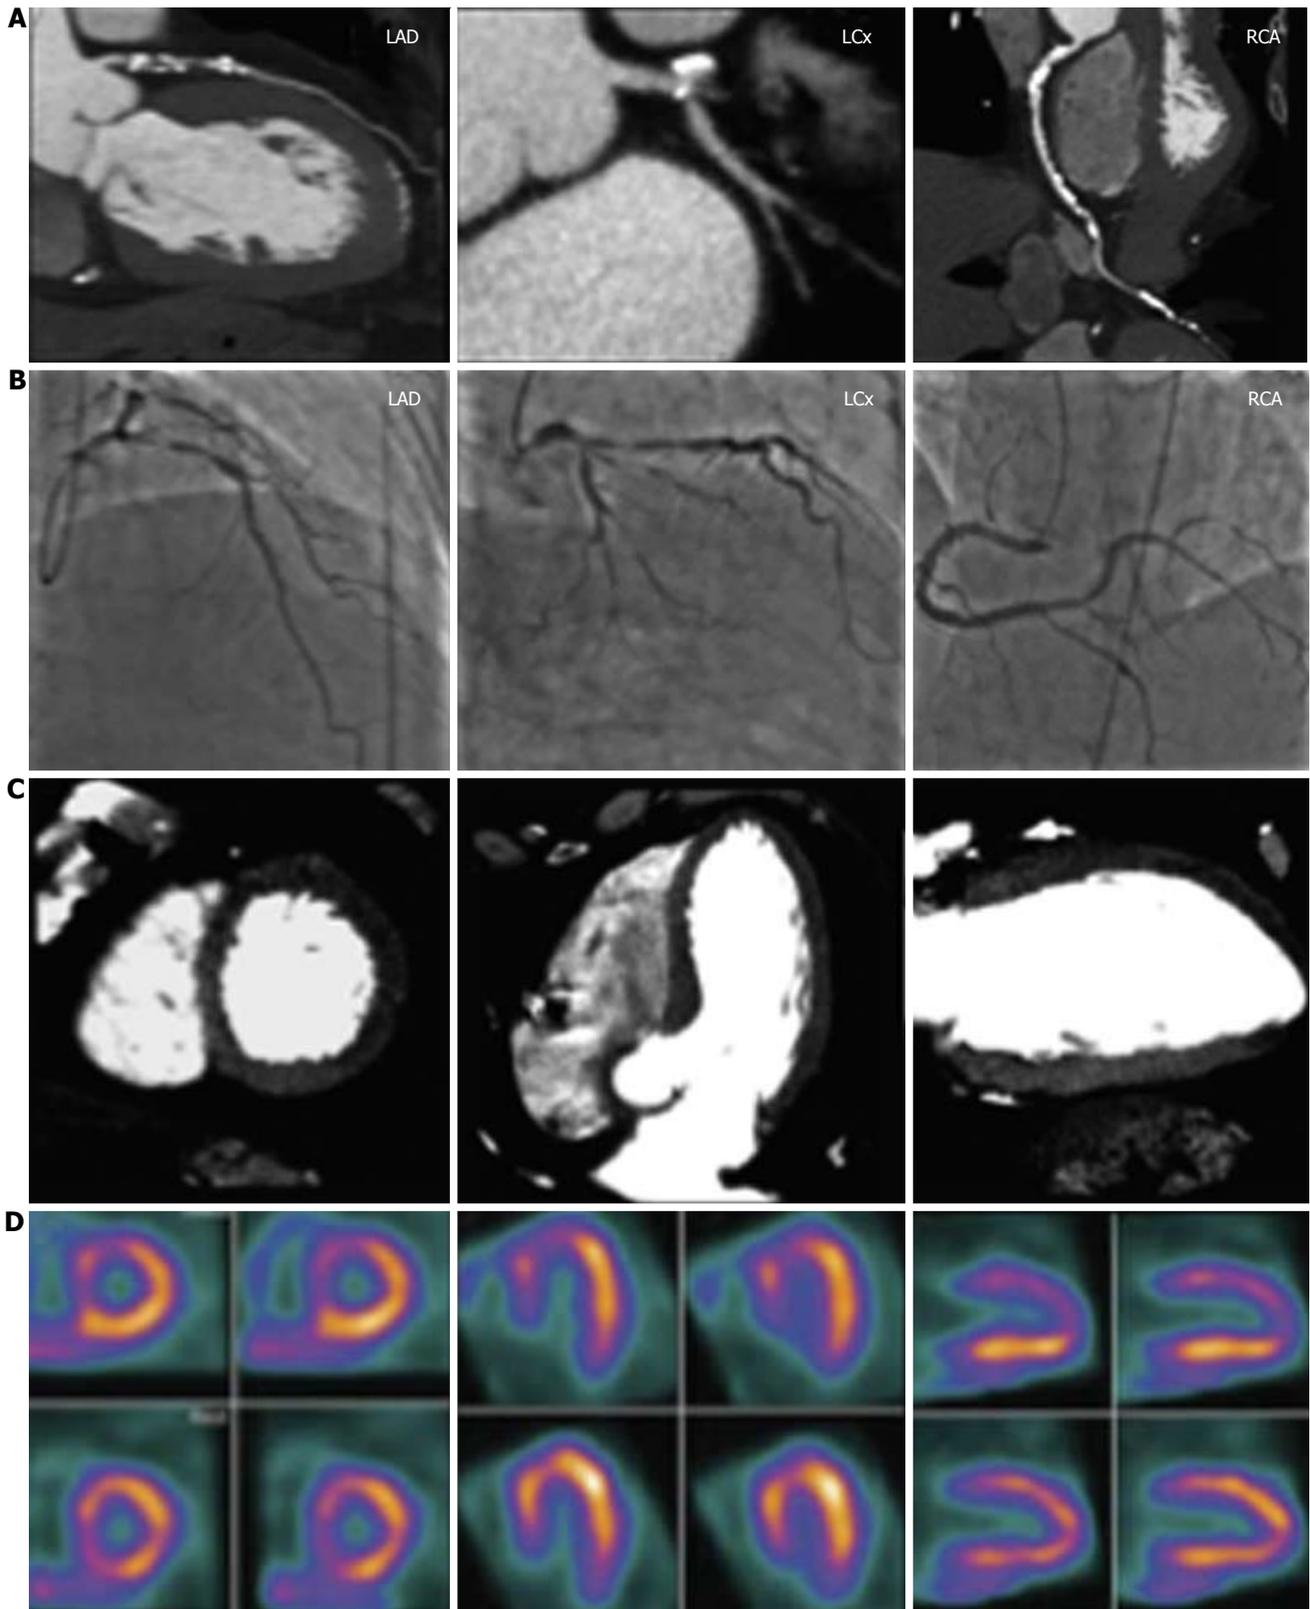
A complete CORE320 imaging data set for a 64-year-old male without prior history of coronary artery disease with chest pain symptoms^[50]. The left anterior descending coronary artery revealed a 96% diameter stenosis by computed tomography angiography (CTA) (row A) and an 85% diameter stenosis by invasive coronary angiography (ICA) (row B). The computed tomography myocardial perfusion (CTP) (row C) study revealed a mild defect in the distal anteroseptal wall, and moderate defects in the basal anteroseptal, the basal anterior, the distal anterior, and apical walls, while the single photon emission computed tomography (SPECT) (row D) study revealed moderate defects in the distal anterior, the distal anteroseptal, the basal anteroseptal and apical walls. The left circumflex artery revealed an 87% diameter stenosis by CTA, a 79% diameter stenosis by ICA, mild defects in the distal inferoseptal and distal inferolateral walls, and moderate defects in the distal anterolateral and distal anterior walls by CTP, and a moderate defect in the distal anterior wall by SPECT. The right coronary artery revealed a 60% diameter stenosis by CTA, a 77% diameter stenosis by ICA, a mild defect in the distal inferoseptal wall by CTP, and no myocardial perfusion defects by SPECT.
